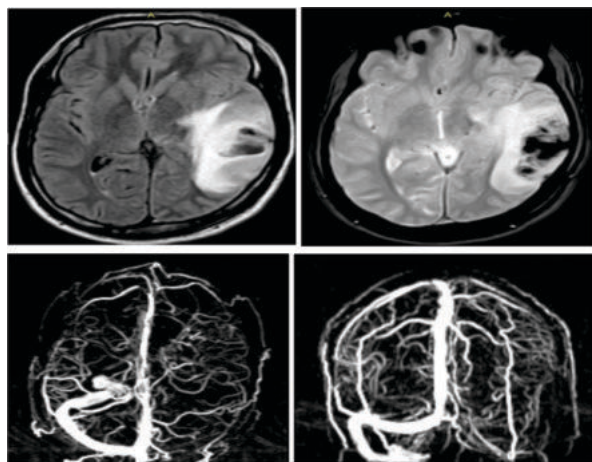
a) Axial FLAIR image showing high signal intensity in left parieto-temporal lobar region. b) Axial GRE sequence showing blooming suggesting venous hemorrhagic infarct. c) & d) MR venogram images showing loss of flow related signal intensity involving left transverse and sigmoid sinuses suggestive of thrombosis.
